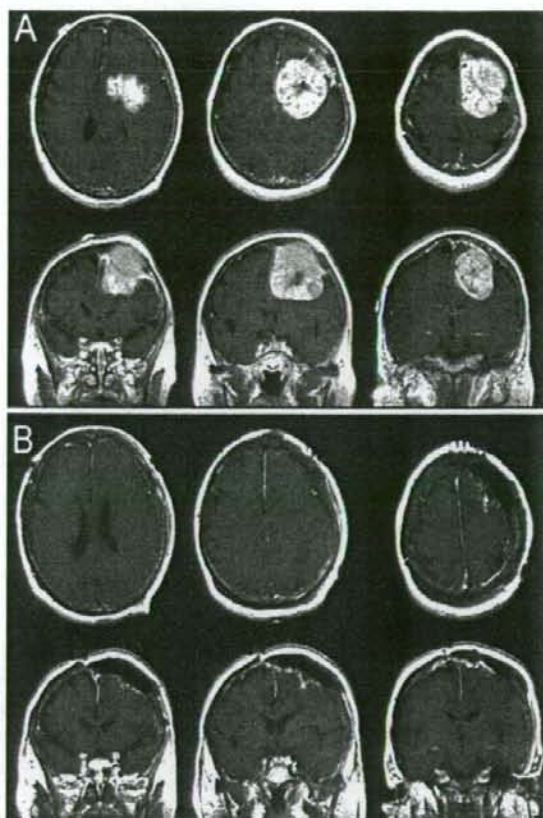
Gadolinium-enhanced T<sub>1</sub>-weighted MR images. A: Preoperative images showing the large tumor with a dural tail sign that reached the superior sagittal sinus. Skull invasion is evident. B: Postoperative images obtained 24 hours after surgery. No enhancing lesion related to the meningioma was observed.
